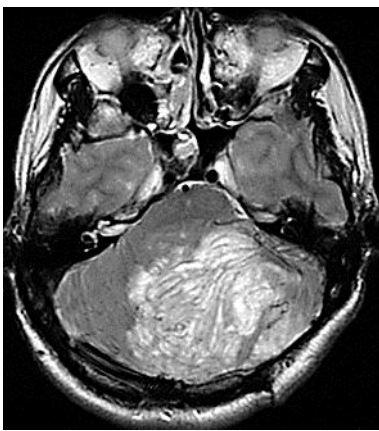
T2-weighted MRI revealed a distinct tiger-striped appearance with abnormally oriented folia in the left cerebellar hemisphere, extending to the vermis.
